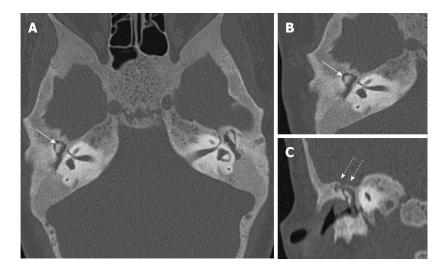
Axial high resolution computed tomography images. (A and B) showing soft tissue opacification in bilateral middle ears (A) with erosion of head of head of malleus (arrows). Coronal reformatted CT image (C) showing thinning and erosion of tegmen tympani (dotted arrows) secondary to cholesteatoma.
